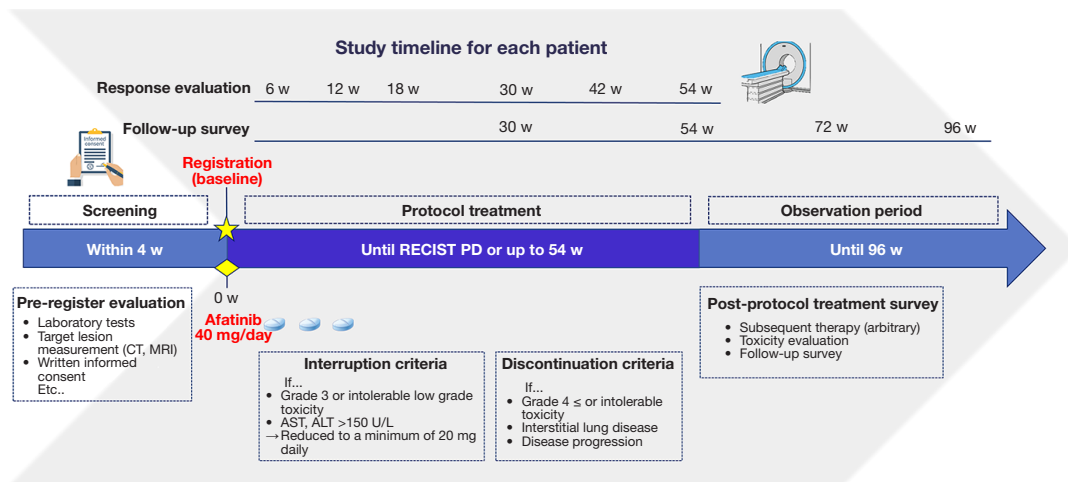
Study timeline for each patient is presented. CT, computed tomography; MRI, magnetic resonance imaging; AST, aspartate transaminase; ALT, alanine transaminase; w, week; RECIST, response evaluation criteria for solid tumors; PD, progressive disease.
